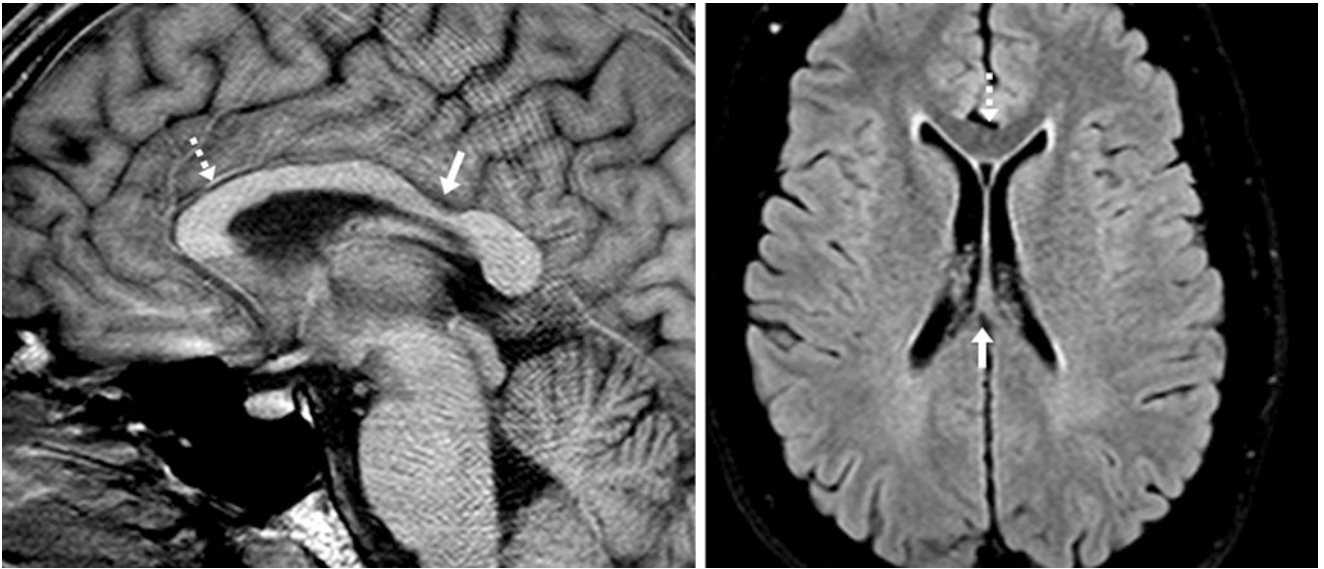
A 46 year old with an MRI obtained to rule out an aneurysm (the MR angiogram was negative). There was a normal, thin callosal isthmus on a midline sagittal T1WI (arrows, left). An axial FLAIR
